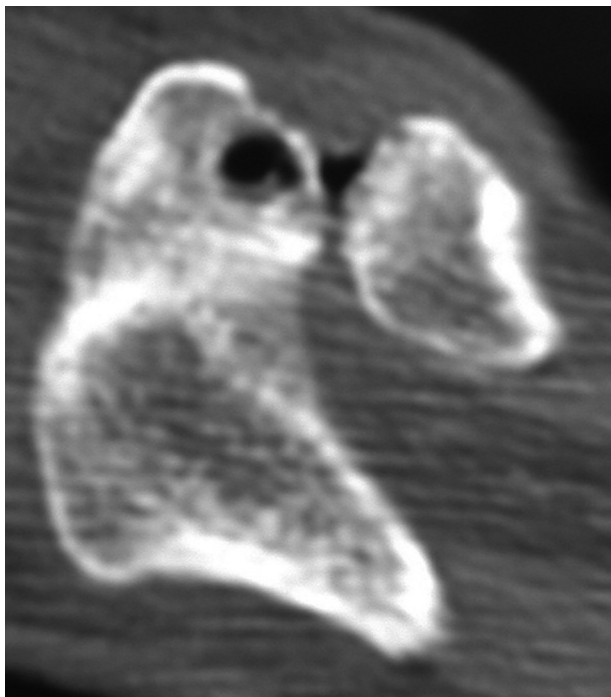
Axial CT image of the right shoulder showing osteoid osteoma in the acromion, next to the acromioclavicular joint.
